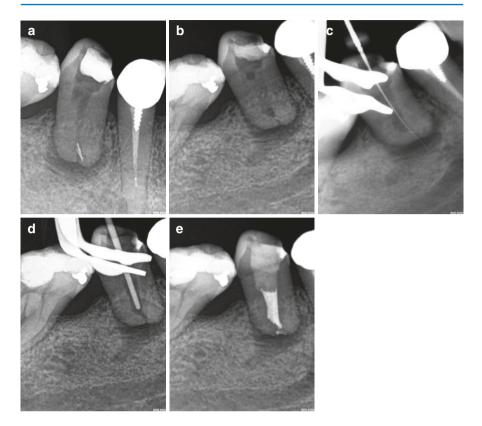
(a) Preoperative radiograph showing three fractured instruments at the apical third of the root canal of a lower mandibular right second premolar tooth with a diagnosis of chronic apical periodontitis. (b) A staging platform was created around the most coronal aspects of the fragments by using modified Gates Glidden drills (sizes #2–4). Thereafter, an RT3 (EMS) ultrasonic tip was activated at low power settings, which trephined dentin in a counterclockwise motion around the fragments. With this action and the vibration being transmitted to the fragments, two of them began to loosen, and they were removed from the canal. (c) Working length determination radiograph showing one fragment inside the canal. (d) The third fragment, as it can be clearly seen in the master cone radiograph, was removed during copious irrigation in the course of root canal instrumentation. (e) Immediate post-obturation radiograph showing complete obturation of the root canal and temporary restoration with glass ionomer cement (Fuji II GC Corporation, Tokyo, Japan) and Cavit (Courtesy of Dr. T. Zarra)
